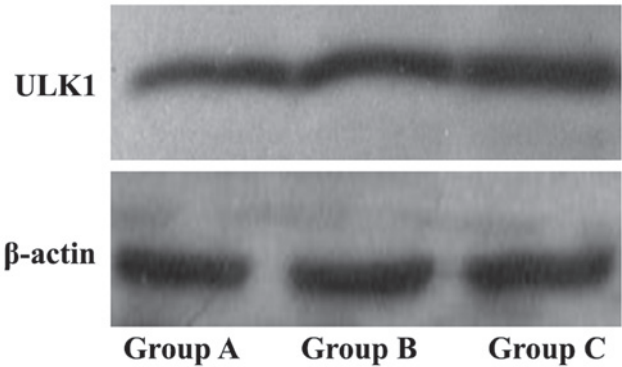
Expression of ULK1 protein is increased in PC3 cells of Group C following irradiation with ultrasound. Expression was examined using western blotting. Group A, no treatment; Group B, cells treated with Lipofectamine® and wt-P53 plasmid; Group C: cells treated with Lipofectamine, wt-p53 plasmid and ultrasound combined with microbubbles. wt-P53, wild-type tumor protein P53.
